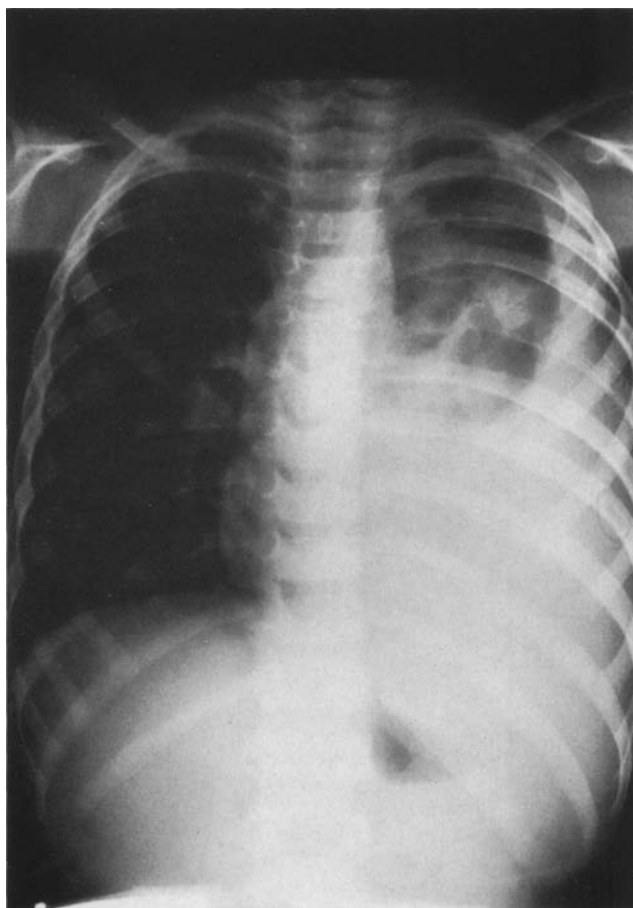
Chest roentgenogram demonstrating a large mass in left hemithorax (4-year-old boy)
